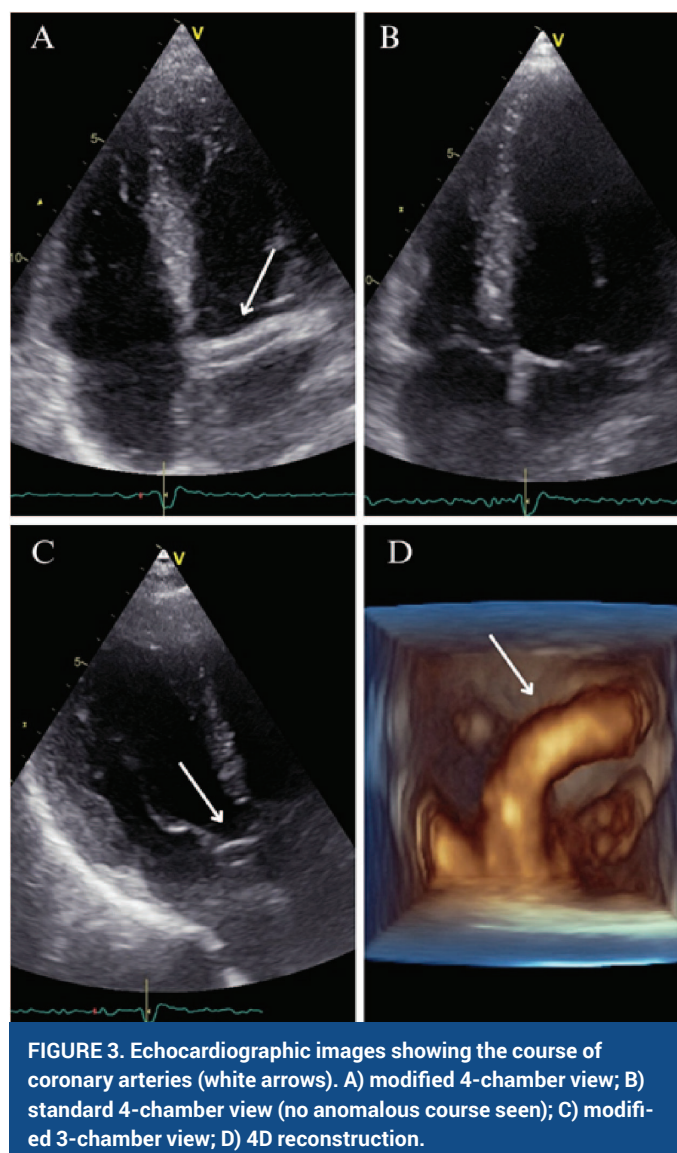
Echocardiographic images showing the course of coronary arteries (white arrows). A) modified 4-chamber view; B) standard 4-chamber view (no anomalous course seen); C) modified 3-chamber view; D) 4D reconstruction.
